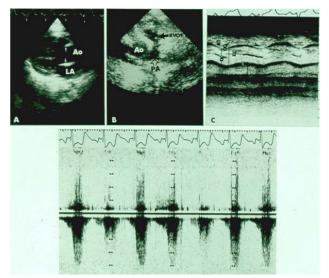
Selected echocardiographic and Doppler recordings from a patient with tetralogy of Fallot, demonstrating a large aorta (Ao) overriding the interventricular septum (A), narrowed right ventricular outflow tract (RVOT) (B), large aorta and a small left atrium (LA) (C) and high Doppler flow velocity (D) across the RVOT. PA, pulmonary artery.
